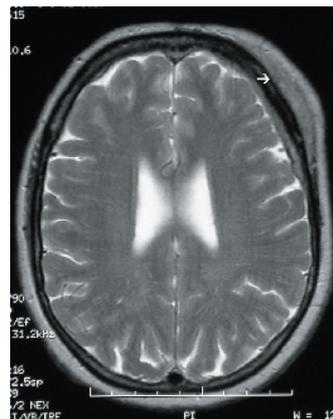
Axial T2W MRI showing subcutaneous mass (arrow) in the left frontoparietal region.
